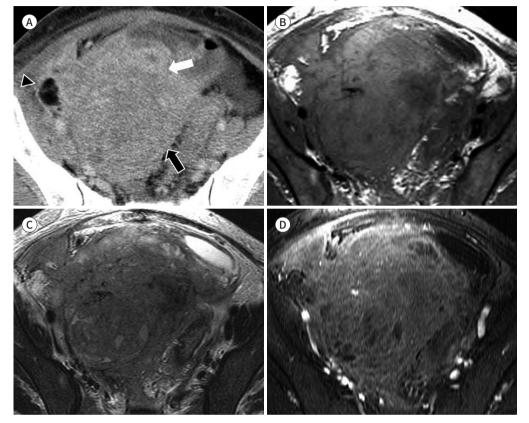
Mesenteric inflammatory pseudotumor in a 62-year-old man with a history of stomach cancer. Axial CT shows an enhancing mass (arrowheads) with soft tissue density and partial, ill-defined margins in the mesentery, mimicking a metastatic tumor.
